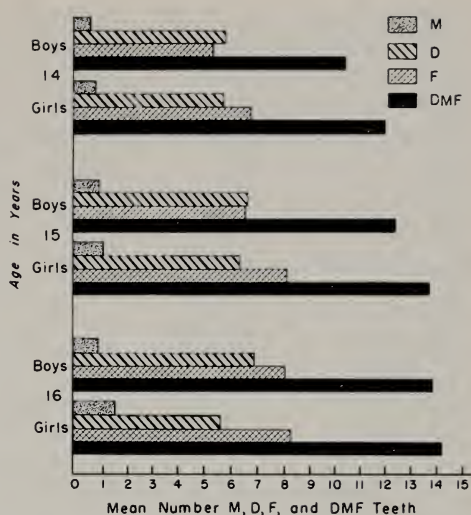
Mean number (without radiographs) of decayed teeth (D), of missing teeth (M), of filled teeth (F), and of decayed, missing, and filled teeth (DMF) for children in areas with 0.0 to 0.3 ppm fluoride in the municipal water supplies, classified by age and sex.
